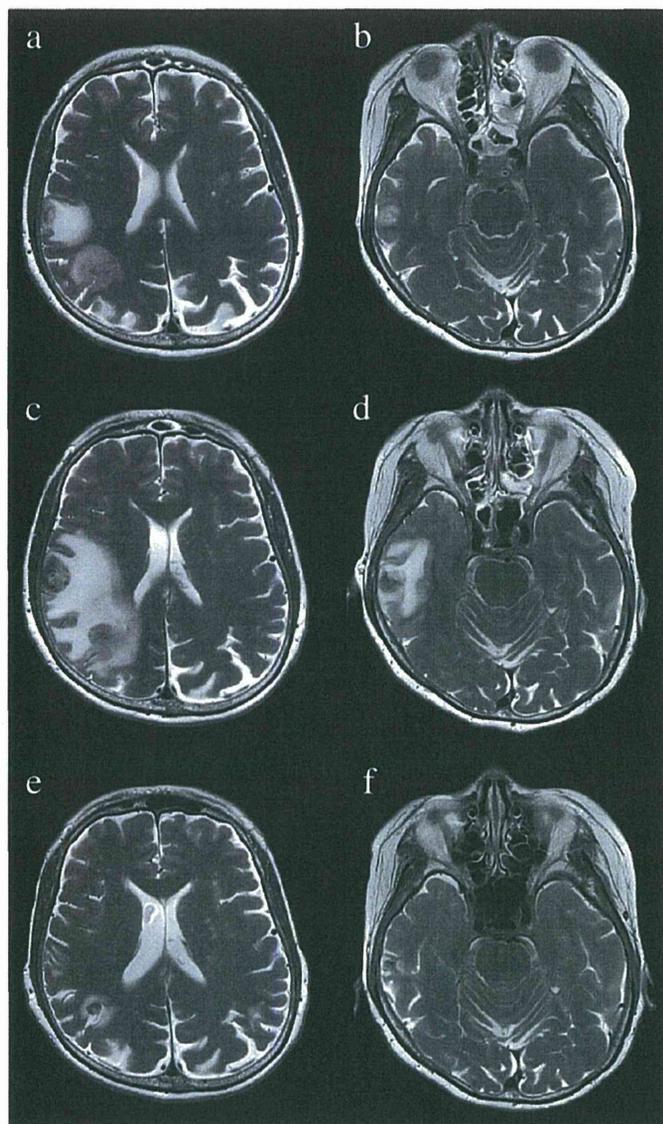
Serial magnetic resonance (MR) findings. Initial MR T2-weighted images obtained on day 2, showing abnormally high signal intensity in the right lateral and parietal lobes (panels a and b). Lesions with abnormally high signal intensity on images obtained at the second MR examination, performed on day 23 (panels c and d). Third MR T2-weighted images obtained on day 200, showing that the abnormally high signal intensity had resolved (panels e and f).
